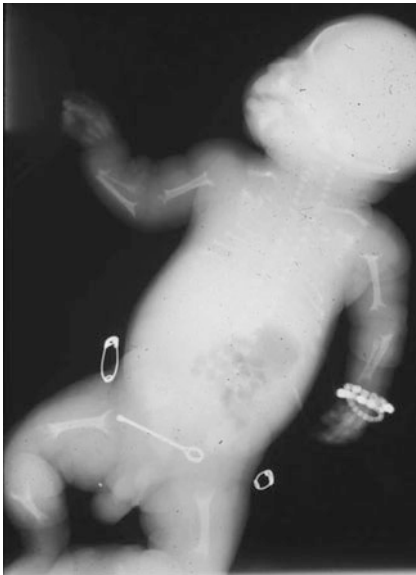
Radiograph of another neonate with hypophosphatasia shows rickets-like metaphyseal cupping (spurs) and poor mineralization of cranial bones
